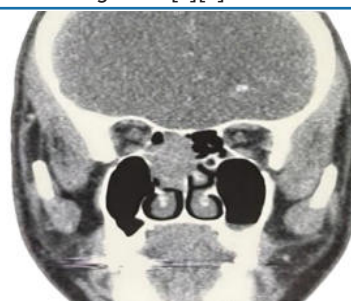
CT PNS showing a mass lesion occupying the right posterior ethmoid and sphenoid regions with erosion of septum.
